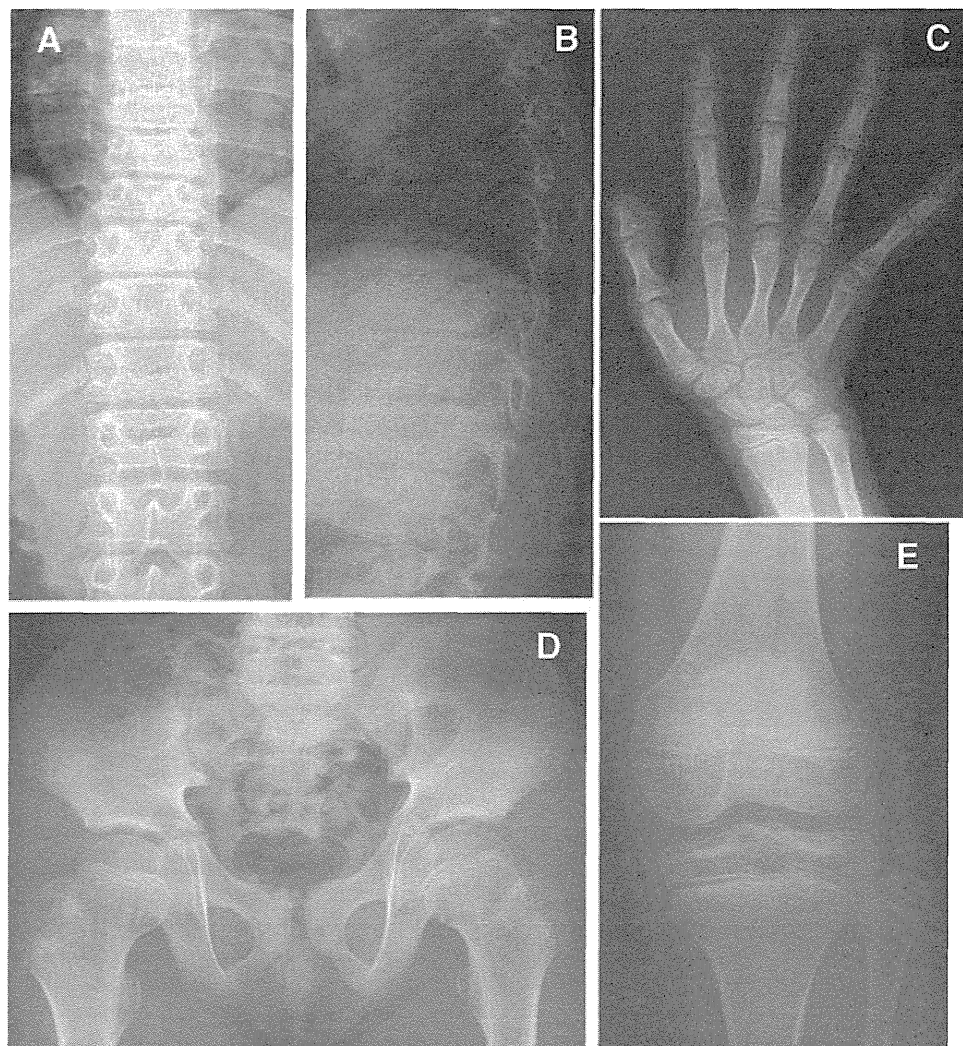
Radiographs of P5 at age 8 years 8 months. (A) Spine anteroposterior (AP). Platyspondyly. Over-faced pedicle is not so distinct. (B) Spine lateral. Flattened vertebral bodies and narrow disc spaces. (C) The right hand AP. Slightly short metacarpals. Phalanges are not so short. The bone age is advanced (12 years by the Greulich-Pyle method). (D) Pelvis AP. Short femoral neck and horizontal acetabulum. Proximal epiphyses are normal. (E) The right knee AP. Unremarkable changes. No fibula overgrowth.
